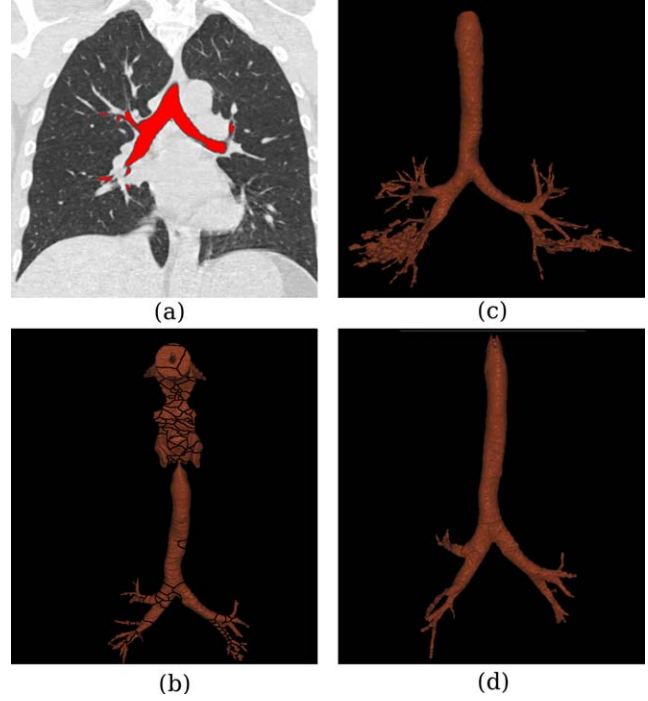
a) Airway masks on a coronal HRCT slice. b) Effects of multiple-path segmentation. The ET region, where such effects are more prominent, is also visible. c) An example of leakages during segmentation. d) Incomplete tree as seen prior to manual correction. Segments in b) and d) are visibly separated
